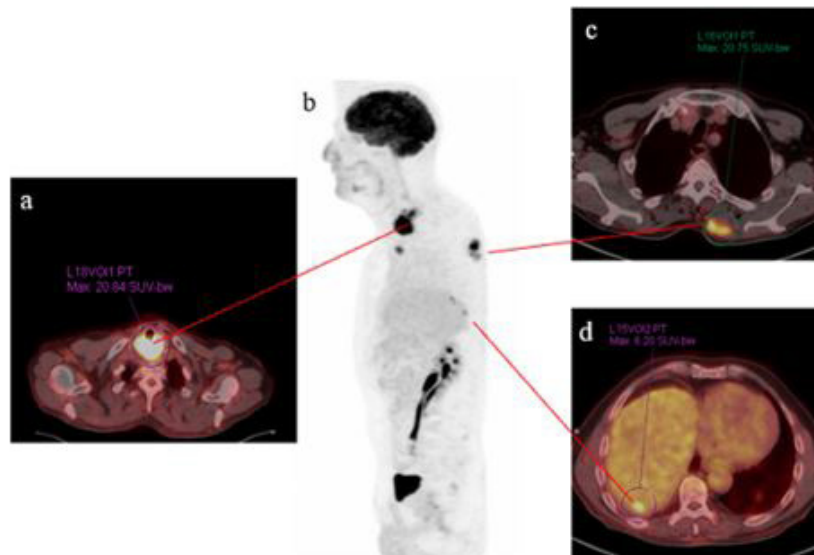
Baseline ^{18}F -fluorodeoxyglucose positron emission tomography scan (^{18}F -FDG PET/CT): (a) High uptake in the cervical mass (SUVmax = 20.84), (b) cutaneous nodules in the back (SUVmax = 20.75), and (d) liver secondary nodule of segment VII (SUVmax = 6.20). (b) PET maximum intensity projection of the patient
